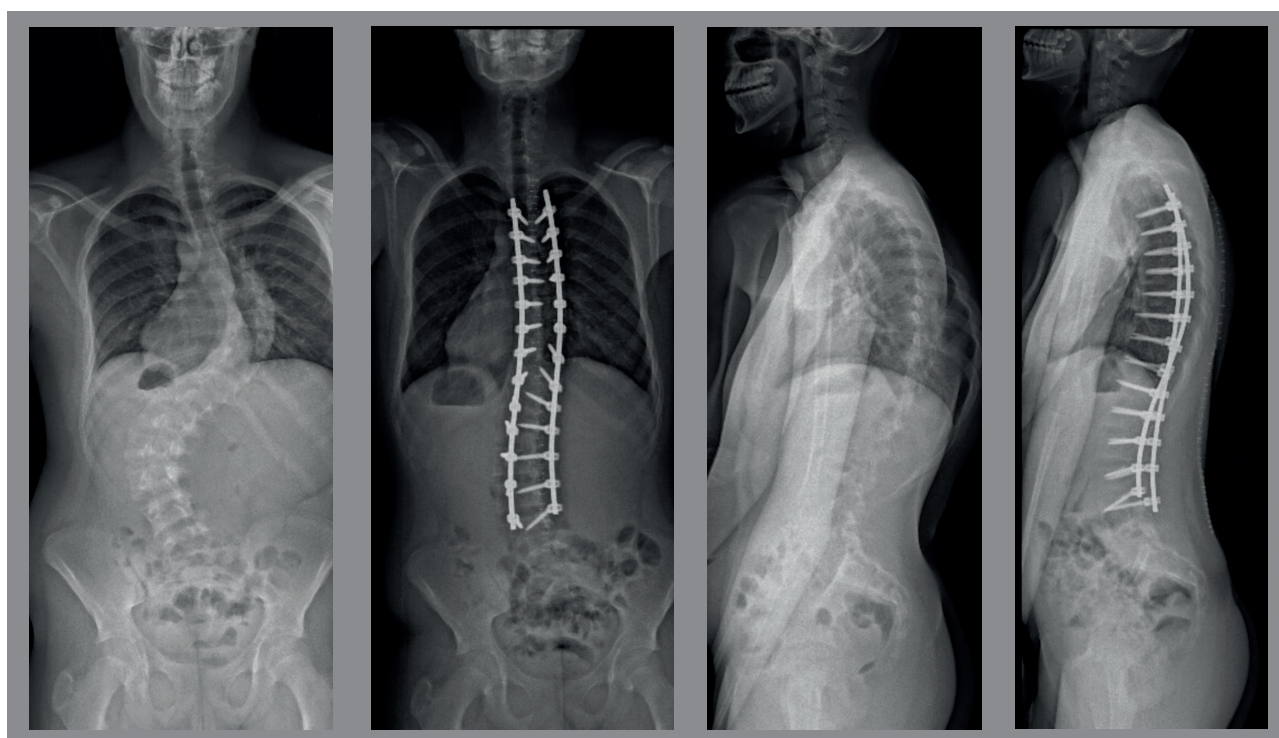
X-rays before and after surgery, Cobb angle 74°.
